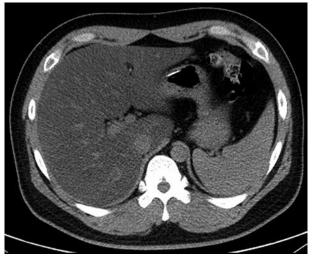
Abdominal computed tomography scans after treatment in the first case
